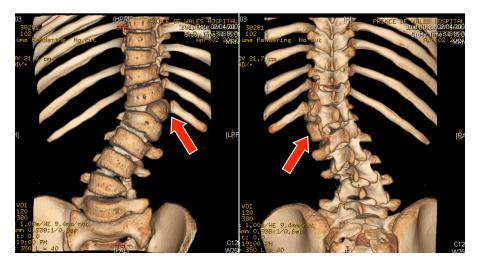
3D-CT scan of patient with left T12 hemi-vertebra.
